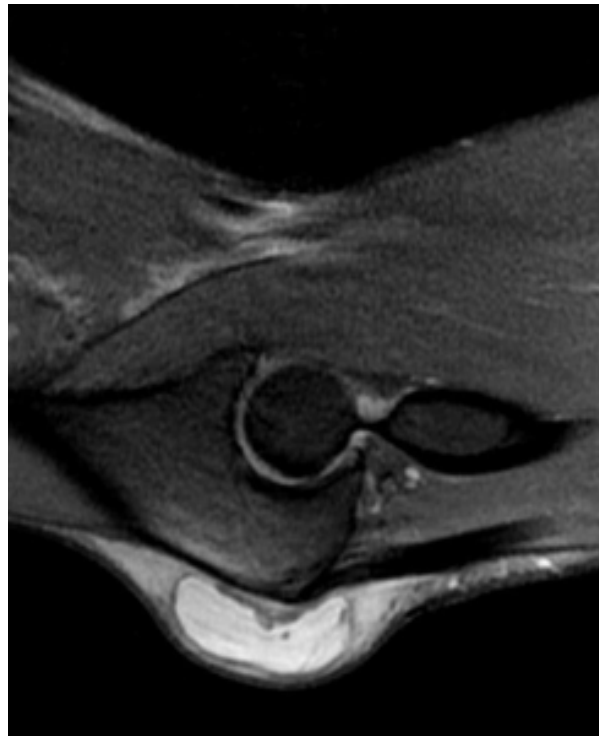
MRI of olecranon bursitis. (From radiopaedia.org
